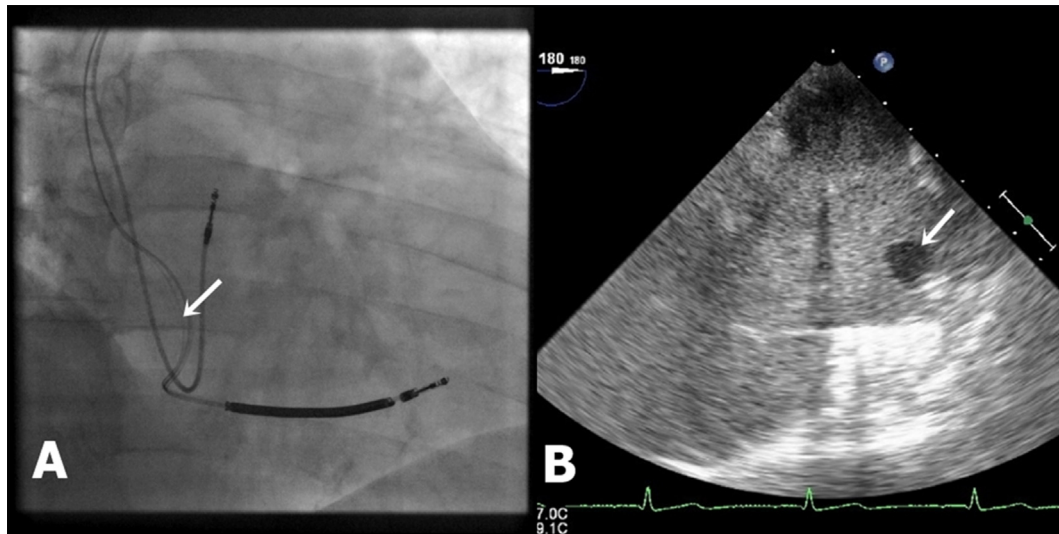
Panel A: Fluoroscopic image demonstrating conductor externalisation (arrow) affecting the implantable cardioverter defibrillator (ICD) lead. Panel B: Contrast transoesophageal echocardiogram image demonstrating a 1 cm mass in the right atrium (arrow) associated with the ICD lead.
